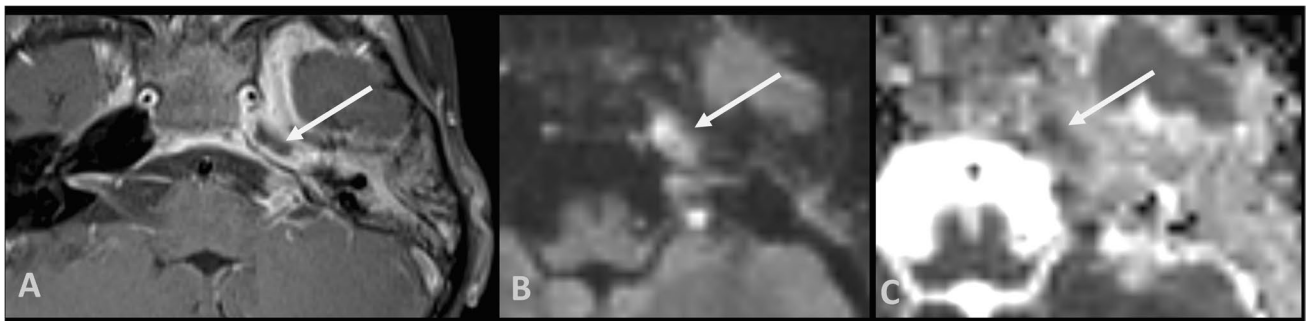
Six-year-old boy. Axial T1WI TSE with fat-suppression A, DWI B and ADC maps C show a rim-enhancing abscess with restricting core (arrows) in the left apex (evolution of an apicitis)
